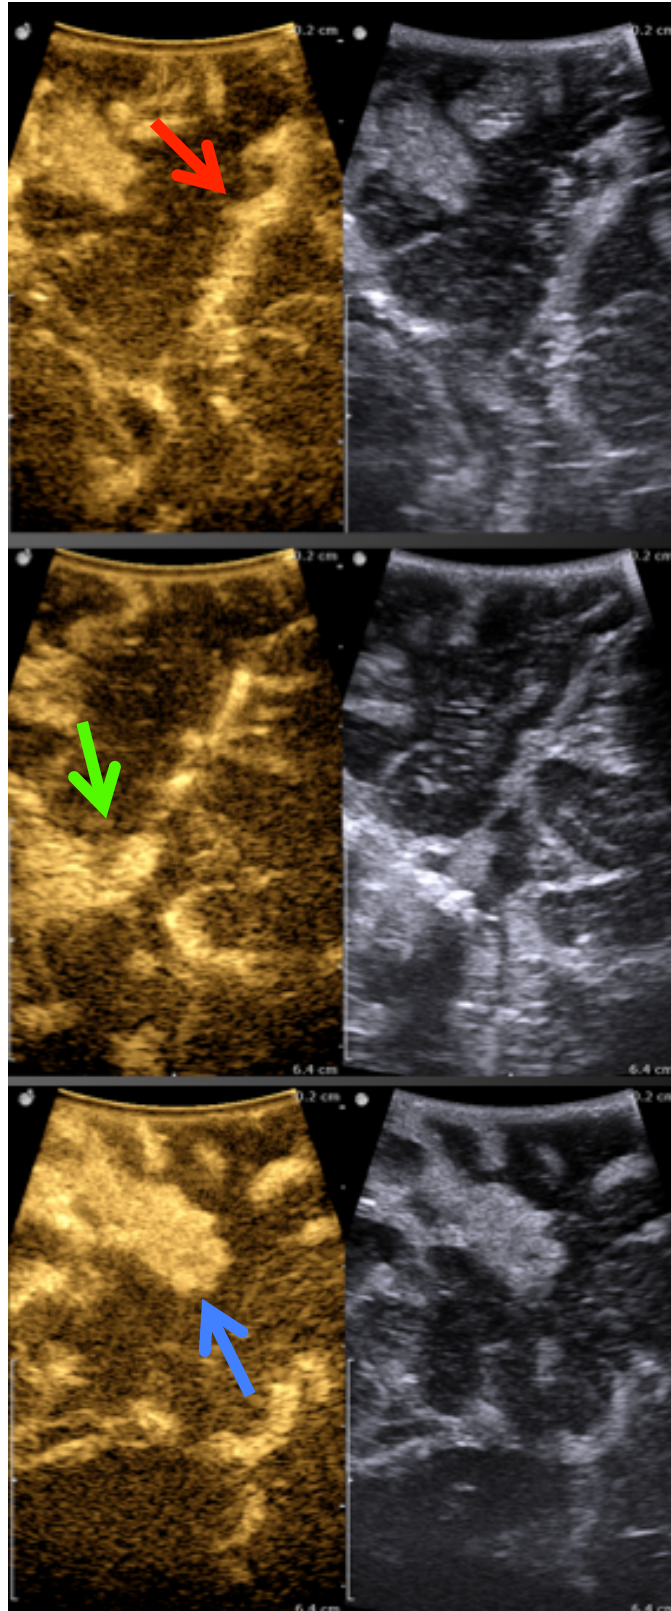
Ultrasound acquisition after administration of the contrast medium: visualization of arterial afferents (red arrow), nidus (green arrow) and venous drainage (blue arrow)
